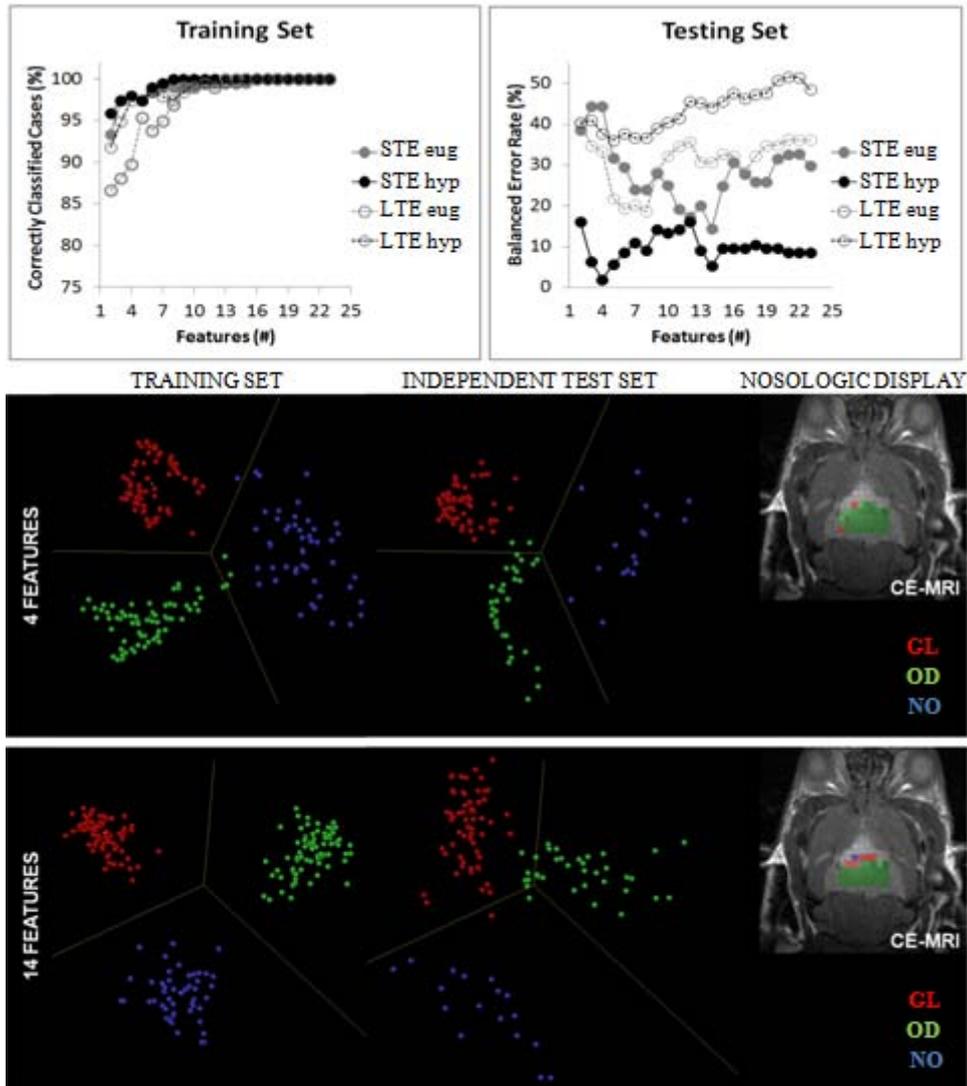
Classifier evaluation and nosologic maps [30]. Top, the descriptive performance of each classifier vs. number of selected features is inspected with bootstrap for the training set (correctly classified cases) and with the BER for the testing set. Bottom, latent space view of the STE during hyperglycemia classifiers, generated with 4 and 14 features, showing the 2D distribution of the training and testing cases used (GL, red; OD, green; NO, blue), and class boundaries (yellow lines); on the right, nosologic-type display of the classification maps obtained for the 3rd OD (heterogeneous grade II, with transitional patches to higher grade) when including it in the testing set, overlaid on a contrast-enhanced (CE) T1- MRI scan.
